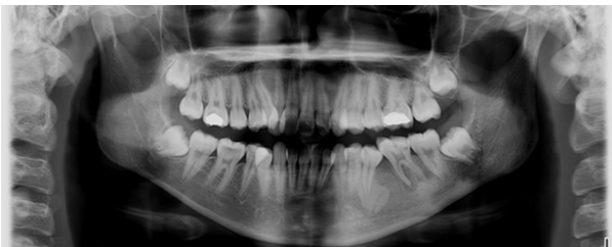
Case 2: Pre-treatment DPT prior to starting orthodontic treatment. Radiopacity present at periapical area of LL5
